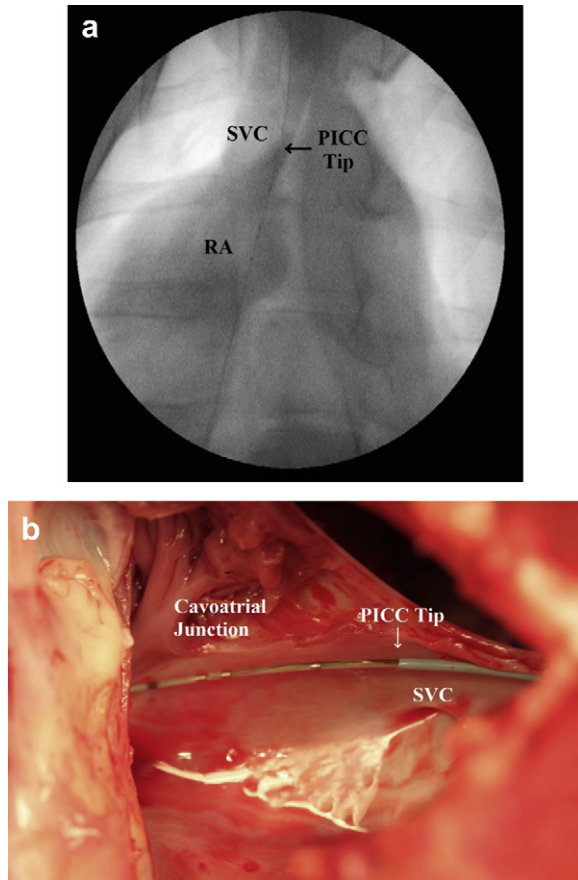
Confirmation of conductance guidewire (CGW) navigation of peripherally inserted central catheter (PICC) tip delivery to the distal superior vena cava (SVC) using (a) fluoroscopy and (b) postmortem direct visualization. The arrows point to the PICC line tip in the distal SVC. Fluoroscopy was not used to aid in the guidance but is shown here as a confirmation. The PICC was offset 2 cm from the middle electrodes and fixed in place during advancement. The X-ray and postmortem image both show that the middle CGW electrodes have accurately located the cavoatrial junction, and the PICC tip is therefore offset 2 cm distal from this location in the distal SVC. In (b), the distal electrode is in the right atrium (RA), the middle measurement electrodes are in the cavoatrial junction (see the trabeculations just above the middle electrodes), and the proximal electrode is in the SVC.
